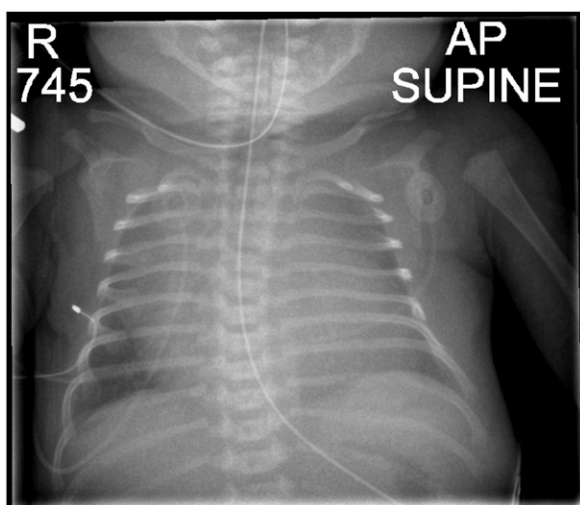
Chest radiograph demonstrating enlarged cardiac silhouette obscuring lung fields.
